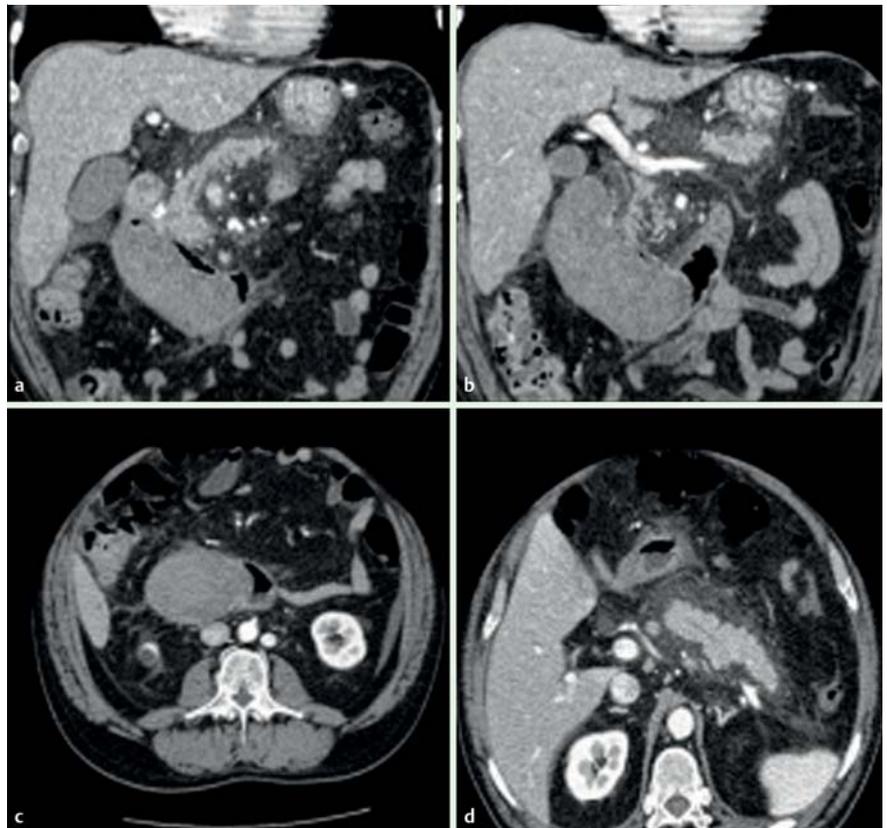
a–c Contrast-enhanced abdominal CT in a 64-year-old man with a 1-day history of abdominal pain and postprandial vomiting. There is a hyperdense expansive lesion (10×6 cm), without contrast enhancement in the arterial phase, in the second and third portions of the duodenum, with mass effect on the duodenal lumen and pancreatic tissue, suggestive of intramural duodenal hematoma. d Diffuse enlargement of the pancreas and increased density of peripancreatic fat tissue. The gastroduodenal artery and pancreatic arterial arcade showed no irregularities.
